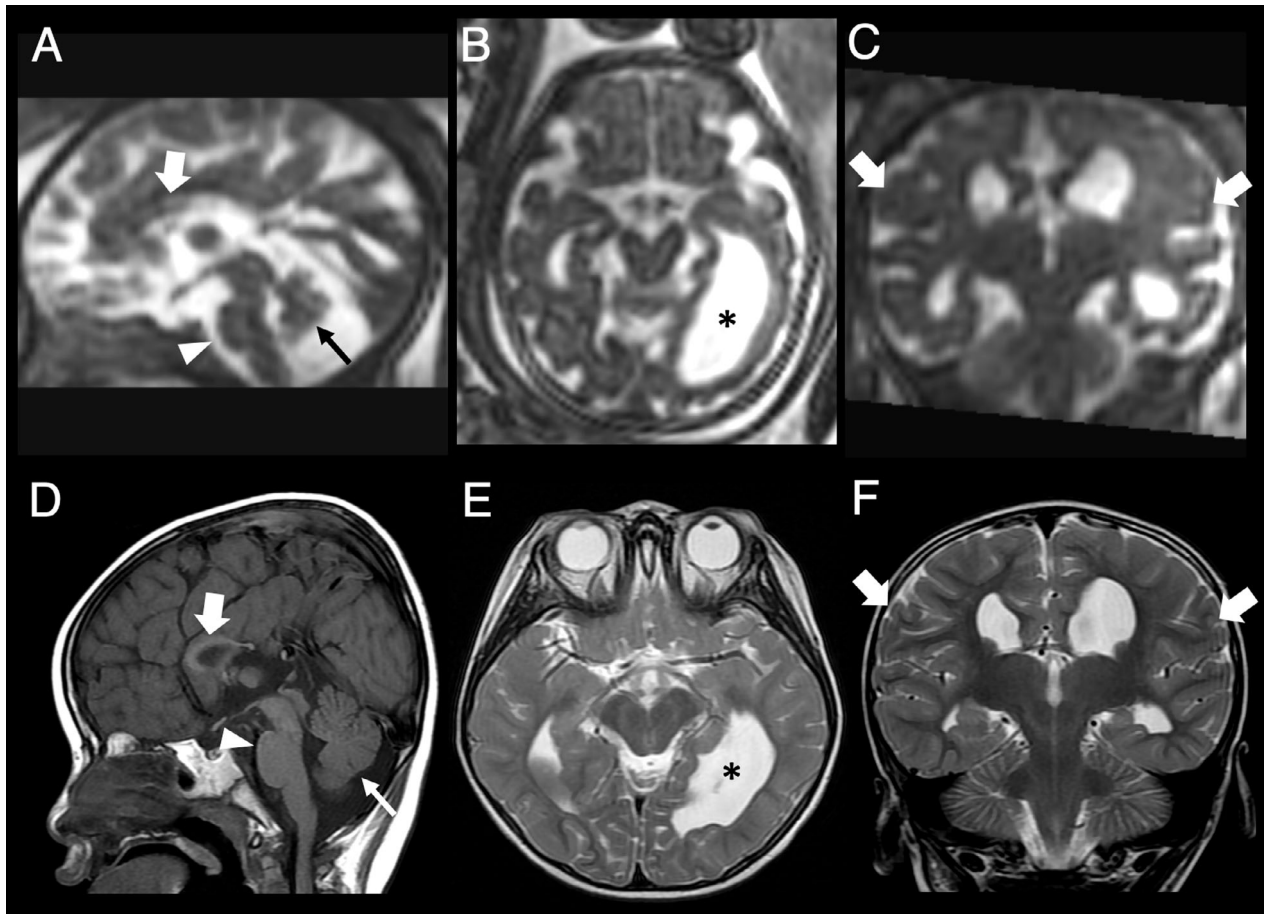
Fetal brain MRI at 32 gestational weeks (A–C) and postnatal MRI performed at 2 years of age (D–F) of subject #10. Sagittal (A, D), axial (B, E), and coronal (C, F) T2-weighted and T1-weighted images reveal the other neuroimaging pattern, characterized by marked white matter volume reduction with asymmetric ventriculomegaly (asterisks, B, E), bilateral dysgyria (thick arrows, C, F), dysgenesis of the corpus callosum (thick arrows, A, D), normal DMJ, mild pontine hypoplasia (arrowheads, A, D), and small vermis (thin arrows, A, D).
